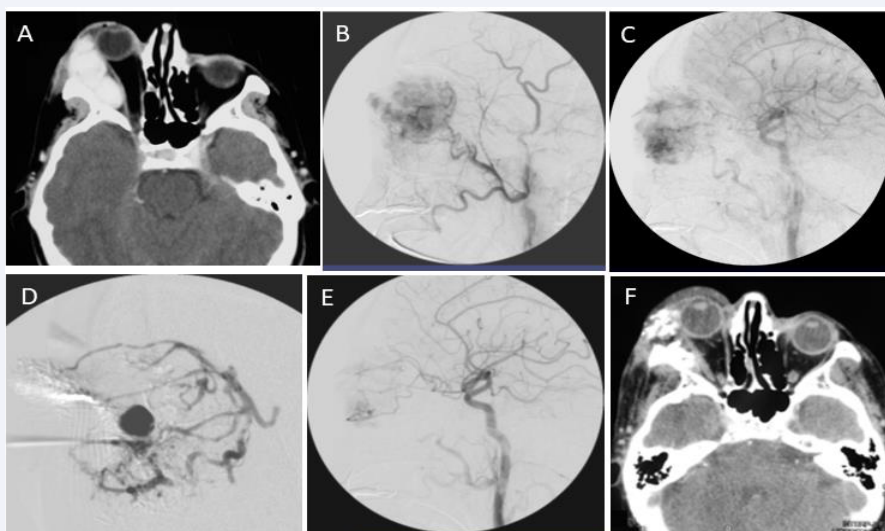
(a) Axial cranial contrast-enhanced CT scan, axial. Notice a lesion located laterally in the extraconal space in the right orbit with bright enhancement showing a multilobulated pattern. (b) External carotid artery. Notice a round blush with multilobulated pattern and delayed venous drainage (c) Common carotid artery angiogram after complete external carotid artery supply embolization with polyvinyl alcohol particles of 250-300 μ. CVM blush remnant was due to ophthalmic artery supply. (d) Second and last direct puncture with gentle injection of n-bca. The injection was stopped as soon as retrograde flow of the embolic mixture to the main terminal branches of the ophthalmic artery was adverted. (e) Common carotid angiogram shows ≥ 95% embolization. (f) Common carotid angiogram shows ≥ 95% embolization.
